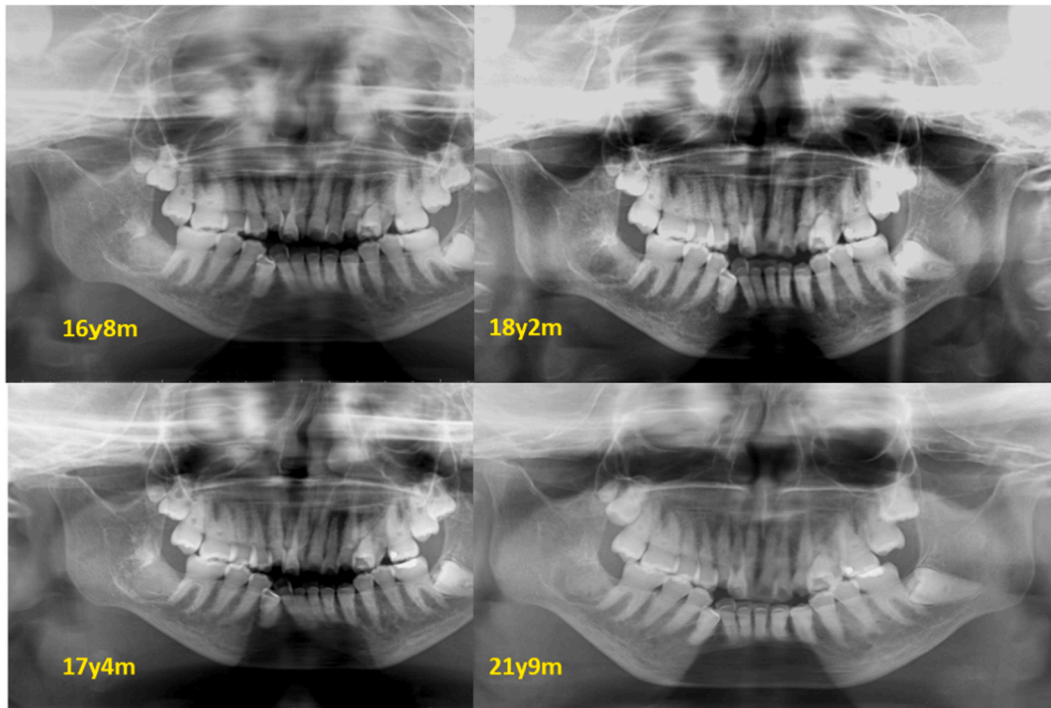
Secular change of the extraction area (Panoramic X-ray photograph).
